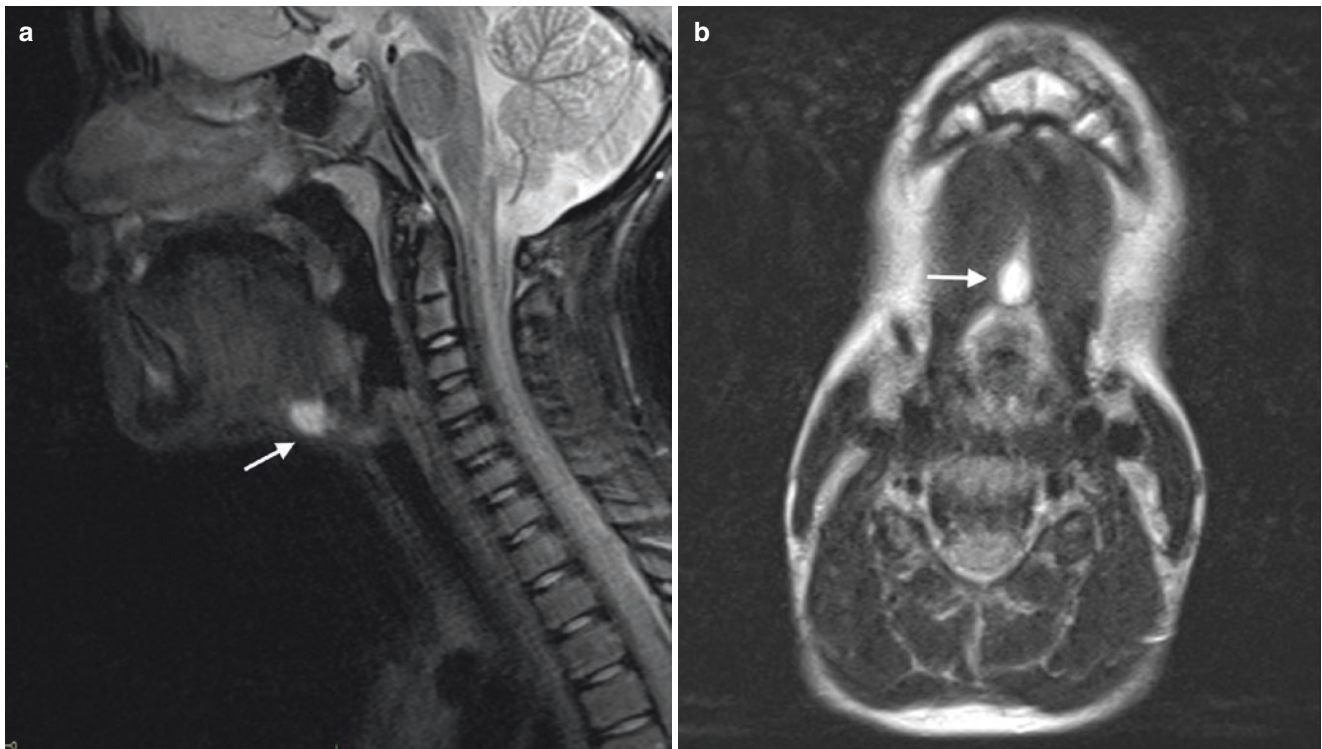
Sublingual thyroglossal duct cyst on MRI. Sagittal T2 STIR (a) and axial T2-weighted (b) MR images show a small midline structure with hyperintense signal (*arrow*) in the sublingual region of the neck
